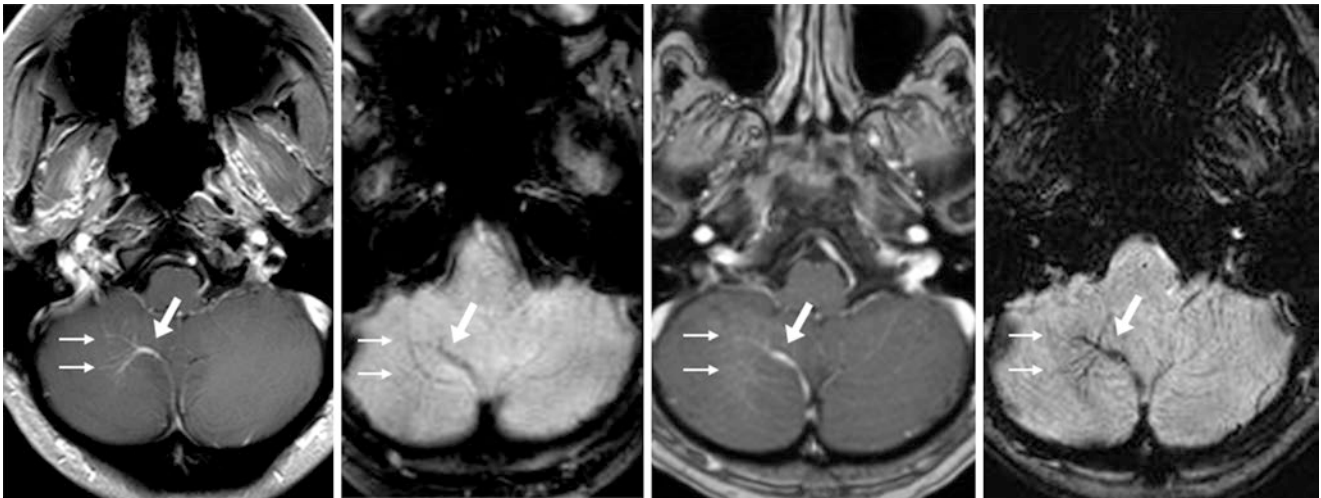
A 49 year old followed for a frontal oligodendroglioma in whom a 1.5T brain MRI noted a small vein (*arrows*) that drained medially from a caput of vessels (*thin arrows*) within the right hemis cerebellum on postcontrast SE T1WI (*left*) and on GE T2*WI (*left middle*). A repeat MRI 8 years later was performed with postcontrast GE T1WI
